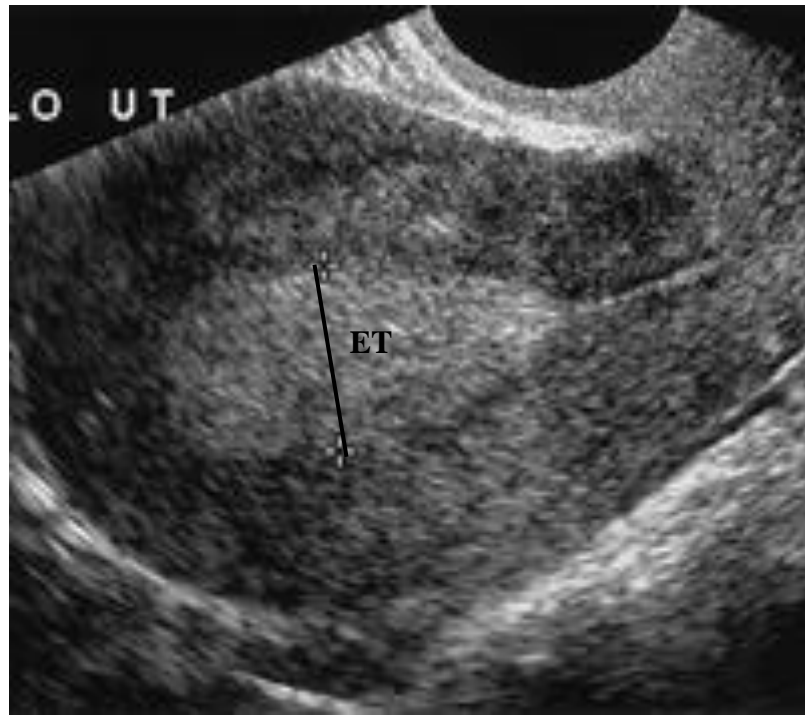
Ultrasound scan demonstrating thickened endometrium in a tamoxifen treated uterus. ET = endometrial thickness. The uterine cavity was normal on hysteroscopy.
